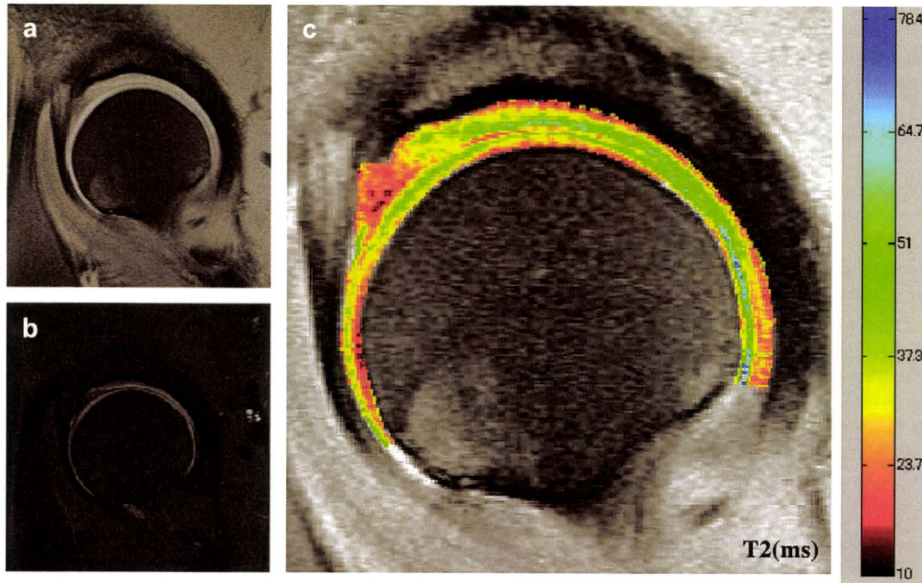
Representative mid-sagittal MR images of a normal volunteer hip (a: 1500/10 ms, b: 1500/45 ms), and corresponding T2 map overlaid on the cartilage region (c). Superior and anterior directions of the hip are toward the top and left of each image, respectively.
